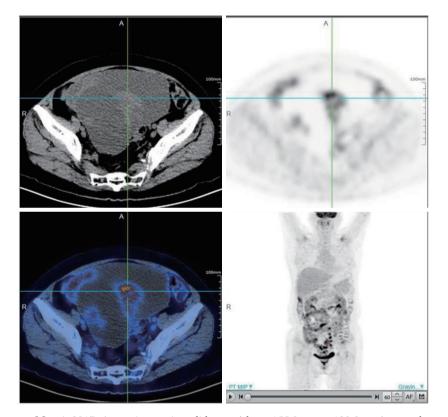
PET-CT images on May 4, 2017. A massive cystic, solid mass (about 155.0 mm \times 129.8 mm) were shown above the uterus in the pelvic cavity. Multiple compartments within the lesion were observed. Nodules in the abdominal wall were accompanied by abnormally increased glucose metabolism, with a maximum SUV value of 9.5. Glucose metabolism in the cystic part was defective. The lesion could not be separated from the bilateral appendages. PET-CT, positron emission tomography/computed tomography; SUV, standardized uptake value; A, anterior; R, right.
